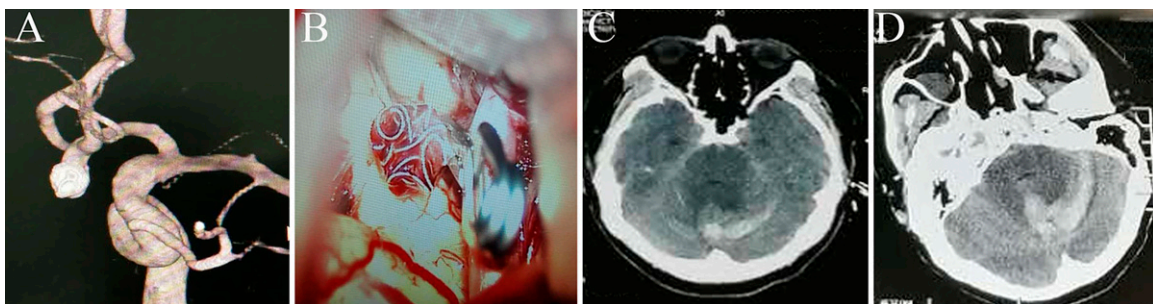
A: DSA follow-up found recurrence of anterior communicating aneurysm after endovascular embolization 2 years ago. B: During the operation, the recurrent aneurysm after embolization was completely clipped without accident. C: At 1 hour postoperatively, CT scan revealed left cerebellar hemisphere and vermiform region hematoma. D: At 8 hours postoperatively, CT follow-up showed increased hemorrhage in left cerebellar and vermis.
